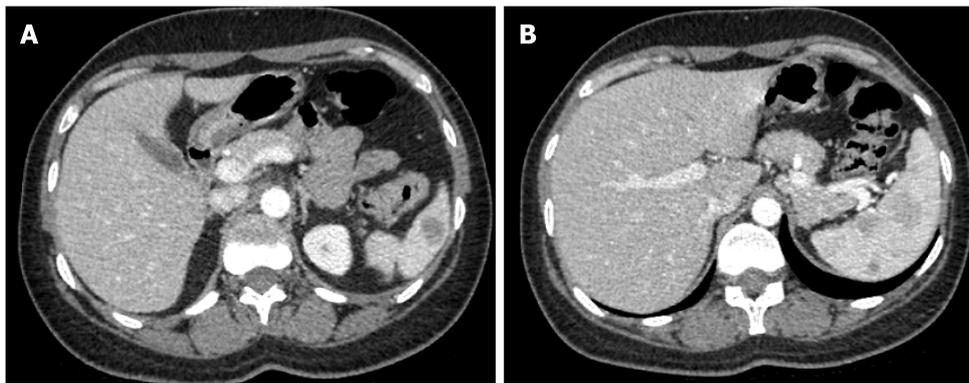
Computed tomography. A, B: Spleen shows multiple circumscribed intermediate density lesions of variable size and varying enhancement, with the largest at the hilum measuring 2.4 cm × 2.1 cm and 2.7 cm × 2.1 cm. The differential diagnosis includes lymphoma, splenic peliosis, infection with multiple abscesses, and metastasis.
